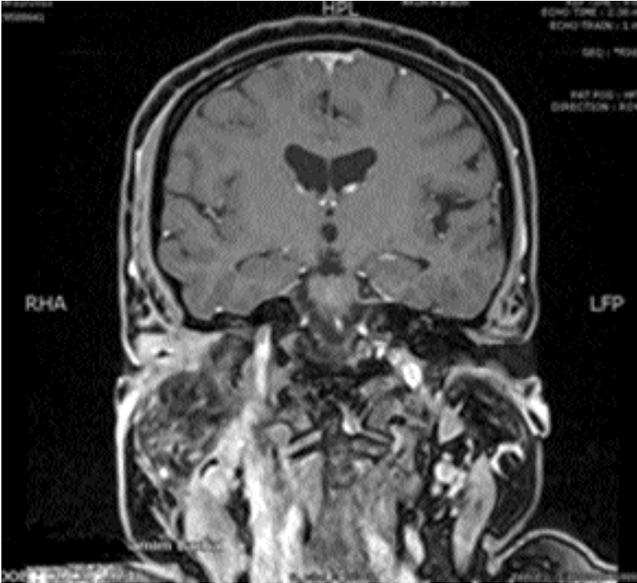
Coronal section of T1 weighted MRI-scan showing inflamed right external auditory canal.
